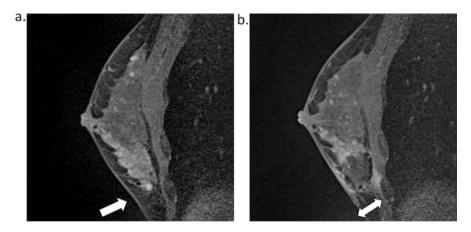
Breast MRI 1–1.5 months after cryoablation to know accurate targeting of the lesion. (a) The lesion before cryoablation (*white arrow*). (b) After cryoablation, targeting the lesion was performed well. Ablated area from the skin and part of the muscle was observed. No thermal injury of the skin is observed
